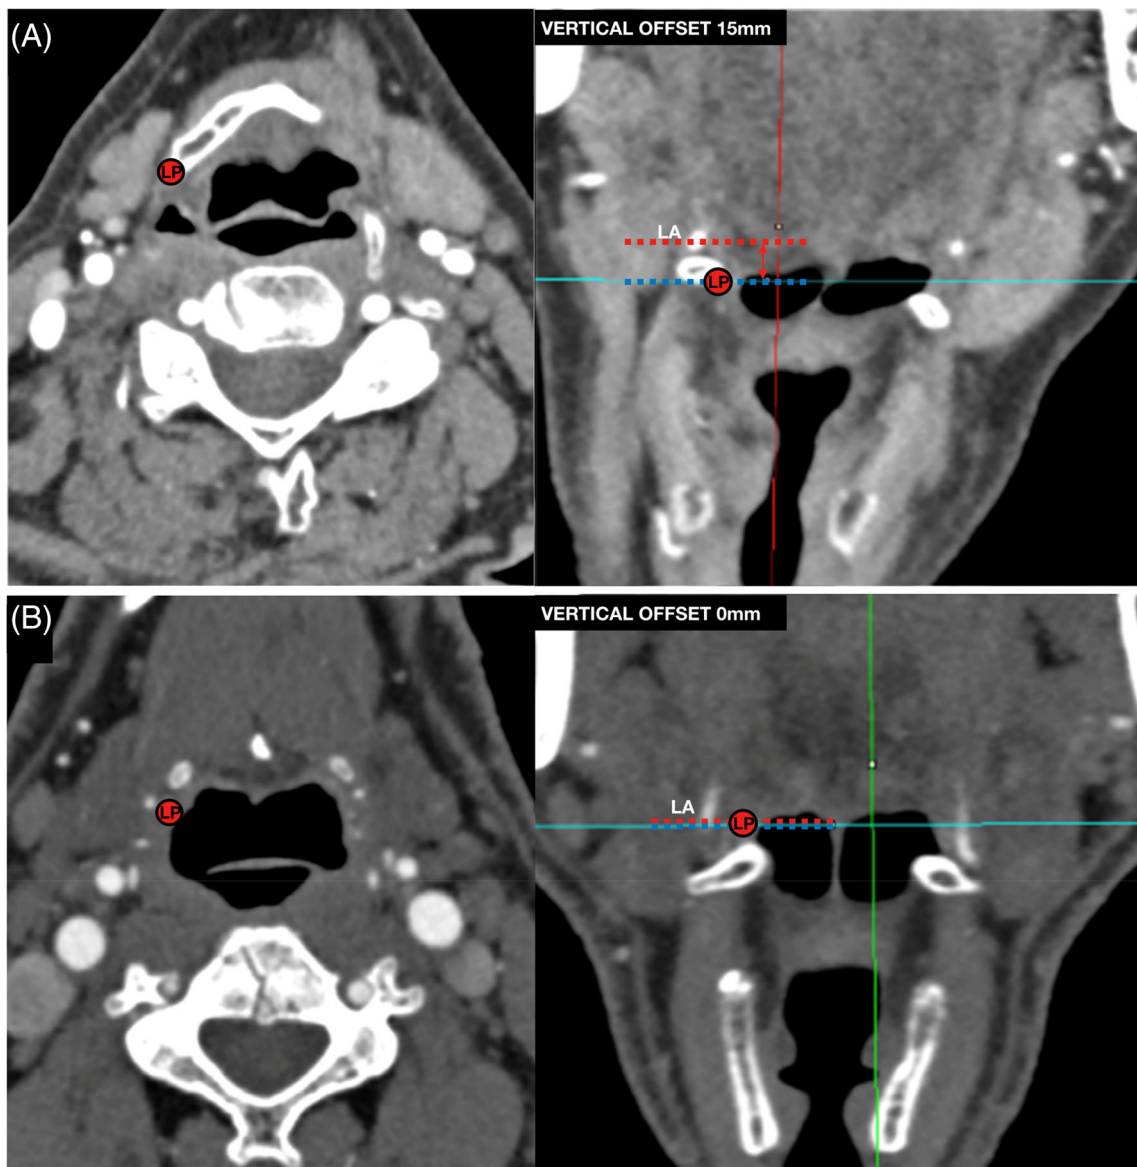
Vertical offset variability of the lingual artery at the LP. CTA multiplanar-reformation-images (MPR) of the neck in two different subjects: the image A shows a peculiar case where the LA lies on a more cranial plane with respect to the LP; in this case, the vertical offset between the planes of the LP (blue dotted line) and the LA (red dotted line) was bilaterally 15 mm (as shown by the red double arrow). The image B shows a more common scenario, where the LA (red dotted line) lays on the same axial plane of the LP (blue dotted line) with a vertical offset of 0 mm. LA, lingual artery; LP, lingual point [Color figure can be viewed at wileyonlinelibrary.com]
